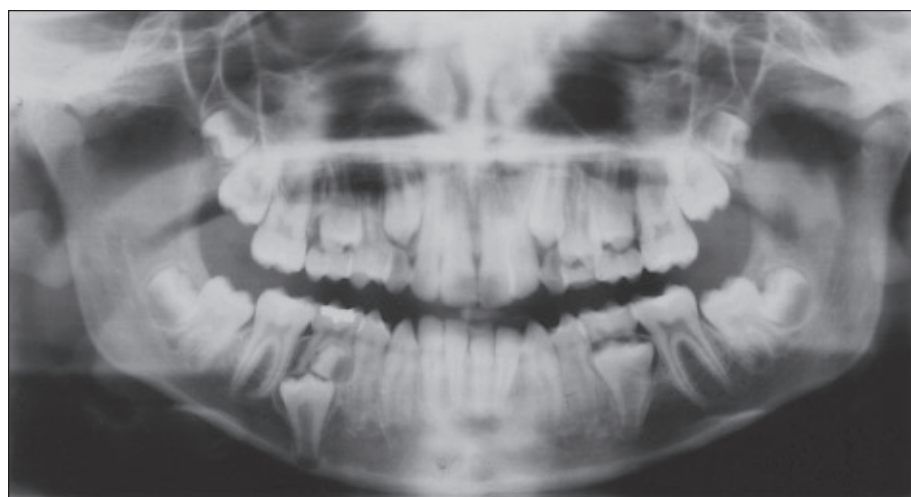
Orthopantomograph of the patient at 12 years old.
